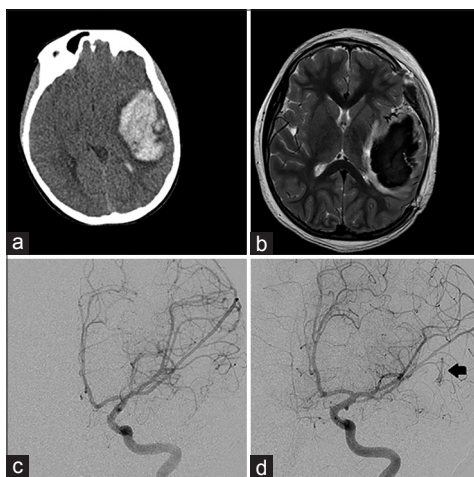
Left frontal hemorrhagic lesion from Case 1. (a) Computed tomography of the head at presentation showed a 9 × 4 × 4 cm hematoma with midline shift. (b) Magnetic resonance imaging brain, T2 sequence showed surrounding vessels but no definite arteriovenous malformation nidus around the large hematoma. (c) Left internal carotid artery digital subtraction angiogram at presentation, without evidence of vascular malformation. (d) Left internal carotid artery digital subtraction angiogram at 4 months post-hemorrhage reveals a left temporal Grade I arteriovenous malformation (arrow)
